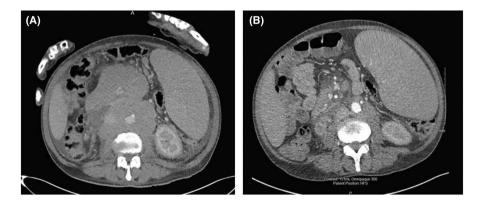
Axial IV contrastenhanced CT image through the abdomen (A) retroperitoneal mass, mesenteric mass, and splenomegaly, prior to commencing ibrutinib therapy (B) regression of lymphomatous masses but massive splenomegaly, after 7 months of ibrutinib therapy when presenting with lactic acidosis
